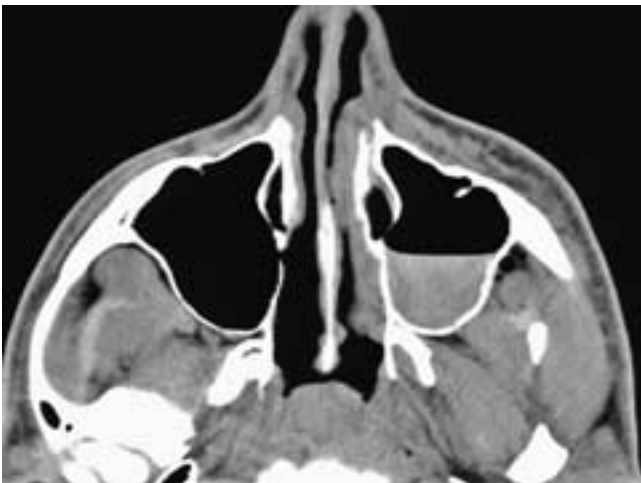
Axial CT scan shows an air-fluid level in the left antrum in this patient with a clinically acute sinusitis. The attenuation of the fluid is that of watery “mucous secretions.” Also note the slight cellulitis in the left facial soft tissues, as evidenced by thickening of the skin, subcutaneous fat, and facial musculature.
